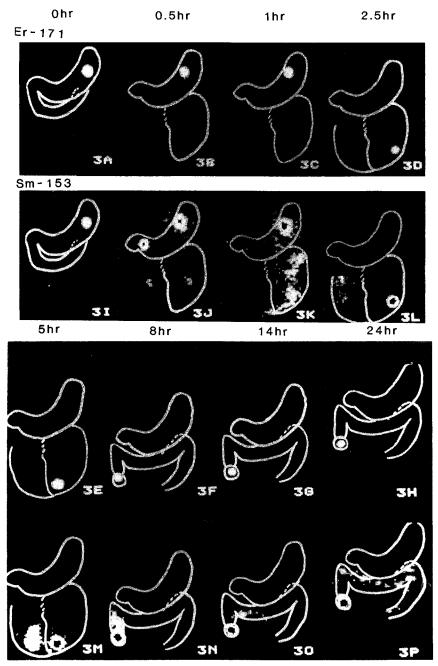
Fasted subject number one gastrointestinal transit of the dual-labeled bilayer tablet. Figs. 3A–H show the non-disintegrating ¹⁷¹Er tablet half and figs. 3I–M represent the disintegrating tablet portion labeled with ¹⁵³Sm. Refer to the text for a description of the scintigraphic images.
